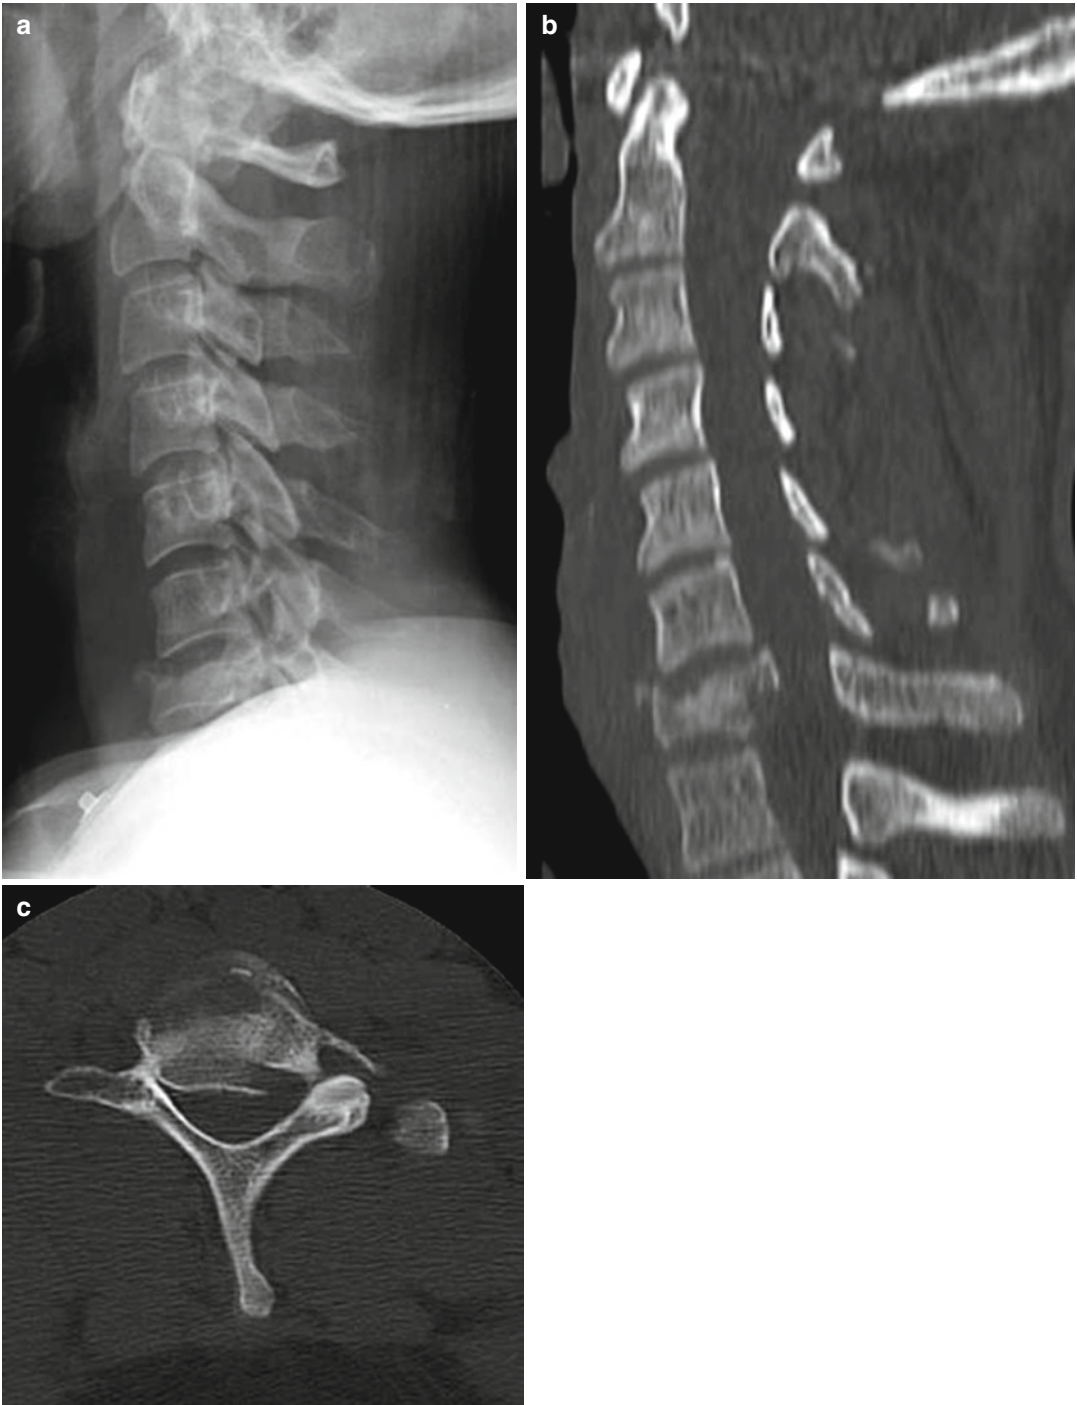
(a–c) Plain X-ray and CT scan of C7 compression fracture
